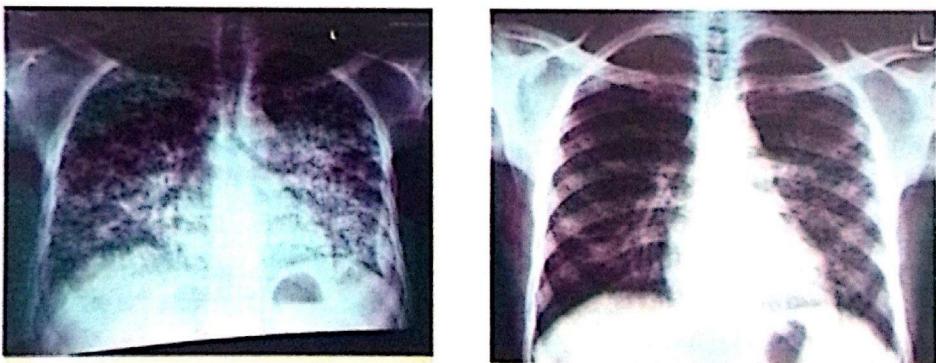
(a) Chest x-ray of index patient at admission (a) and after intensive phase of anti-TB (b)
